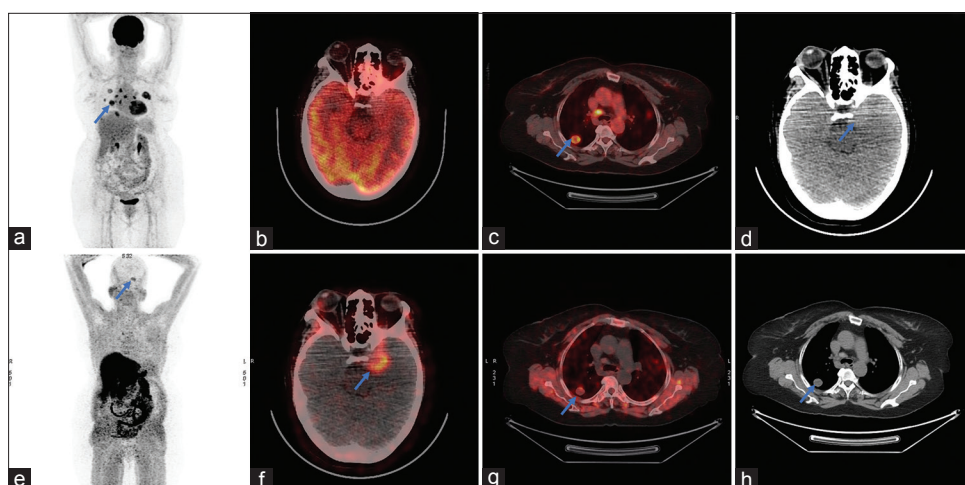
¹⁸F-fluorodeoxyglucose positron emission tomography and computed tomography and ¹⁸F-fluorocholine positron emission tomography and computed tomography maximal intensity projection, cross-sectional computed tomography and fused images showing intensely ¹⁸F-fluorodeoxyglucose-avid (standardized uptake value maximum ~13.1) and moderately choline-avid (standardized uptake value maximum ~4.7) multiple parenchymal and pleural-based lung nodules and mediastinal lymph nodes (arrows in figures a, c, e, g and h). A choline-avid (standardized uptake value maximum 6.5) and non-¹⁸F-fluorodeoxyglucose-avid lesion in the left parasellar location (arrows in figures b, d and f) MIP: Maximal intensity projection
